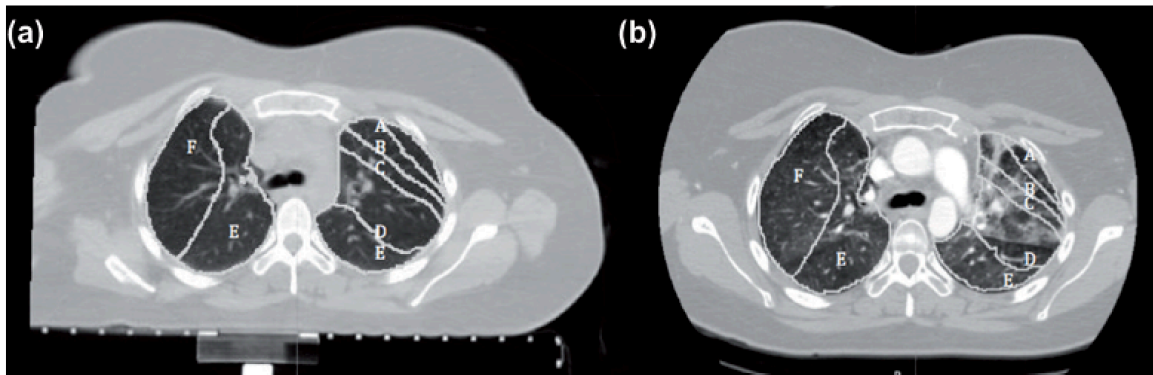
Representative example of image registration with overlaid isodose lines: (A) >40Gy, (B) 30-40Gy, (C) 20-30Gy, (D) 10-20Gy, (E) 5-10Gy, (F) <5Gy. (a) Planning CT scan with contoured isodose lines (b) Post-treatment follow-up CT scan with the contours from the planning scan overlaid via rigid registration.
